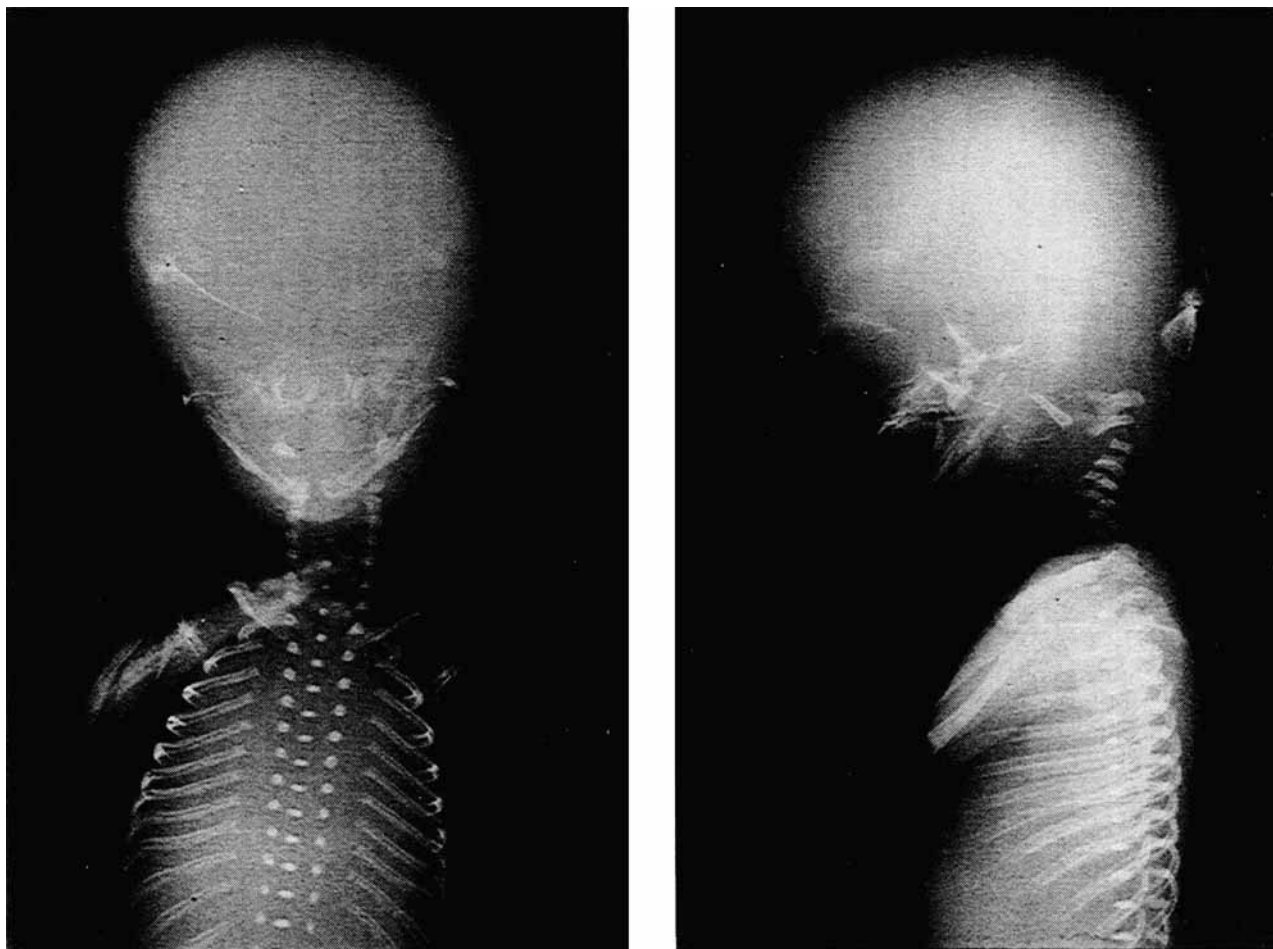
Radiographic frontal appearance (left) of a human fetus (age 15 weeks) showing actual status of ossification in the cranium, the cervical and thoracic vertebrae, and the ribs. Same fetus in lateral projection (right). Note the advanced ossification of the craniofacial skeleton compared with the ossification stage of the neurocranium.
